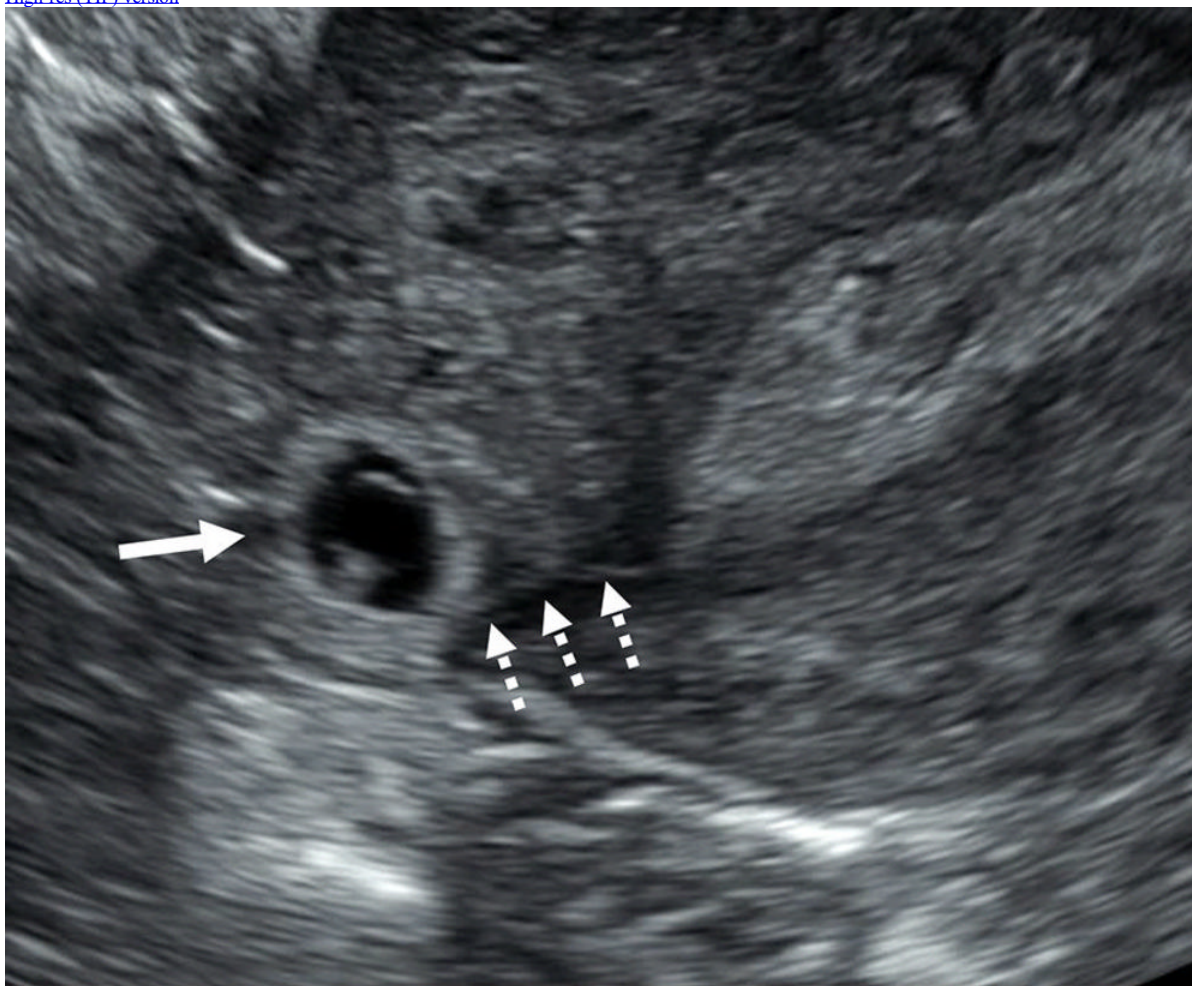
Interstitial line sign. Transvaginal transverse grayscale US image in a 33-year-old pregnant patient shows a right *interstitial ectopic pregnancy* (EP) (solid arrow) at 6 weeks 0 days. In addition to the characteristic sonographic findings of an interstitial EP shown in Figure 10, there is a thin echogenic line (dotted arrows) representing the interstitial segment of the tube. This line connects the endometrium to the ectopic gestational sac and is called the *interstitial line sign*.
